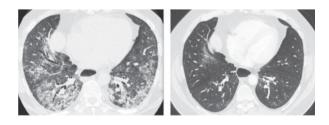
CT Thorax Patient 6 pre- and post-treatment
